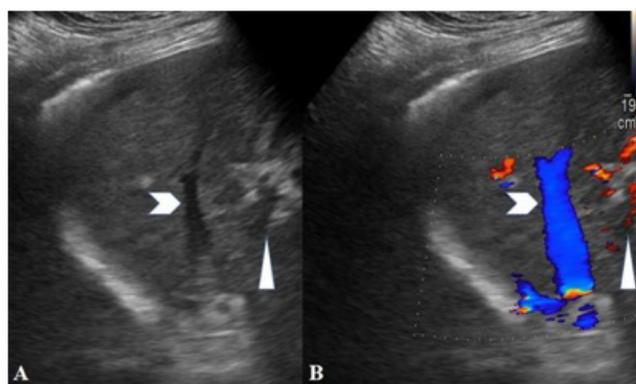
Display of portal and hepatic vein on sonogram. Real-time dual color Doppler sonogram shows the right portal vein (white triangle) near its bifurcation from main portal vein and middle hepatic vein (white arrowhead). (A) Gray scale US imaging. (B) Color Doppler US imaging.
